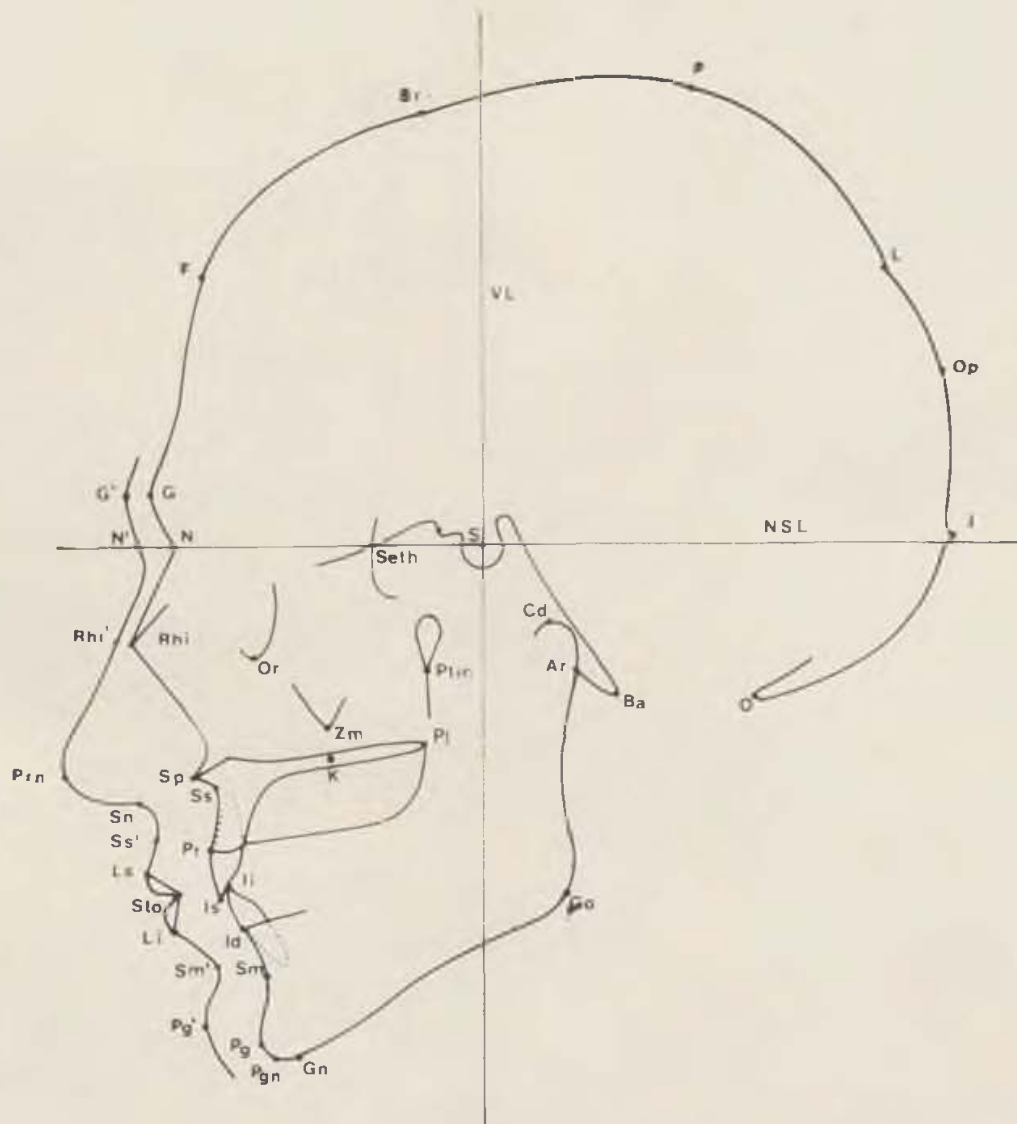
Craniometric points used for the assessment of lateral X-ray films
